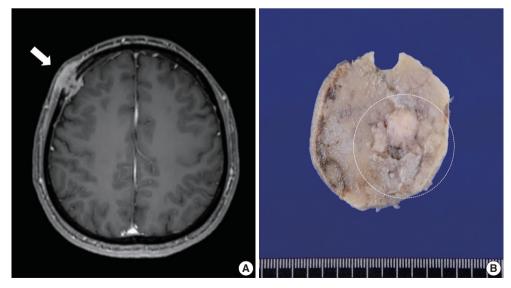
Radiologic and gross findings. (A) Ga-enhanced T1-weighted magnetic resonance imaging shows a transdiploic mass in the frontal scalp involving the dura mater (arrow). (B) Grossly, an ill-circumscribed, whitish solid mass infiltrates the skull (circle).
